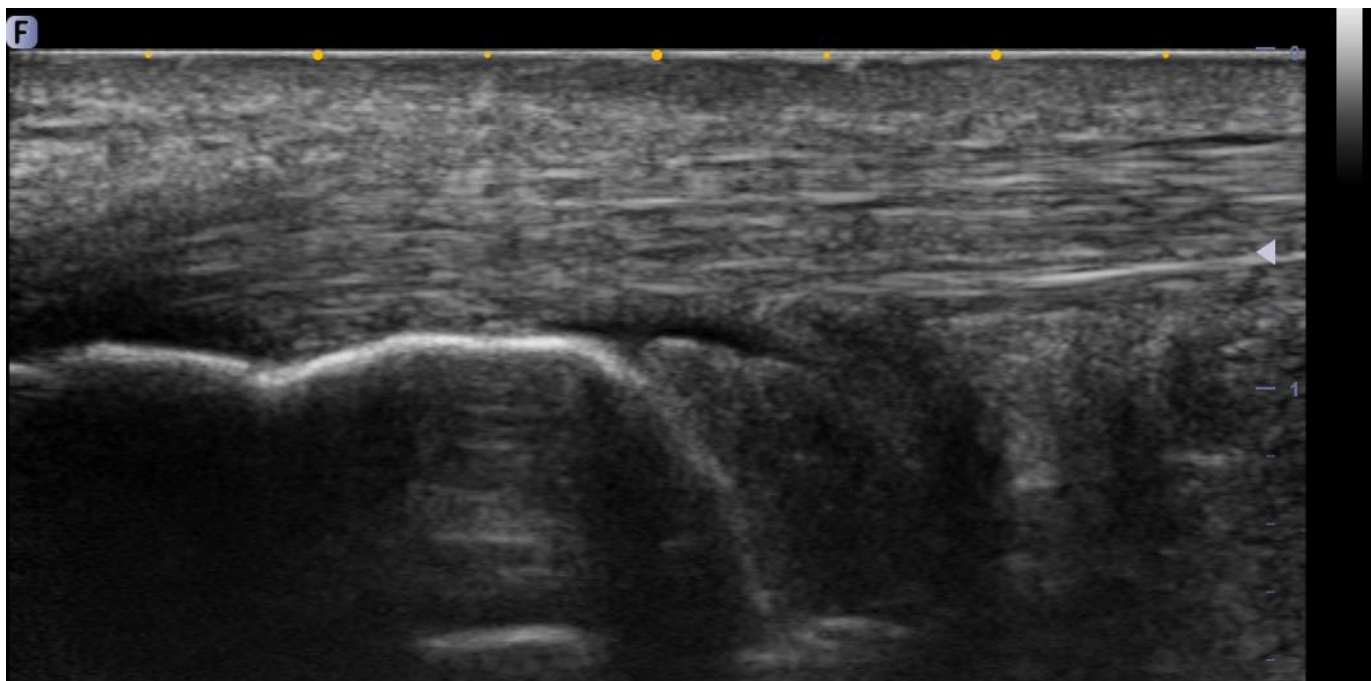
Ultrasound image of the Achilles tendon
